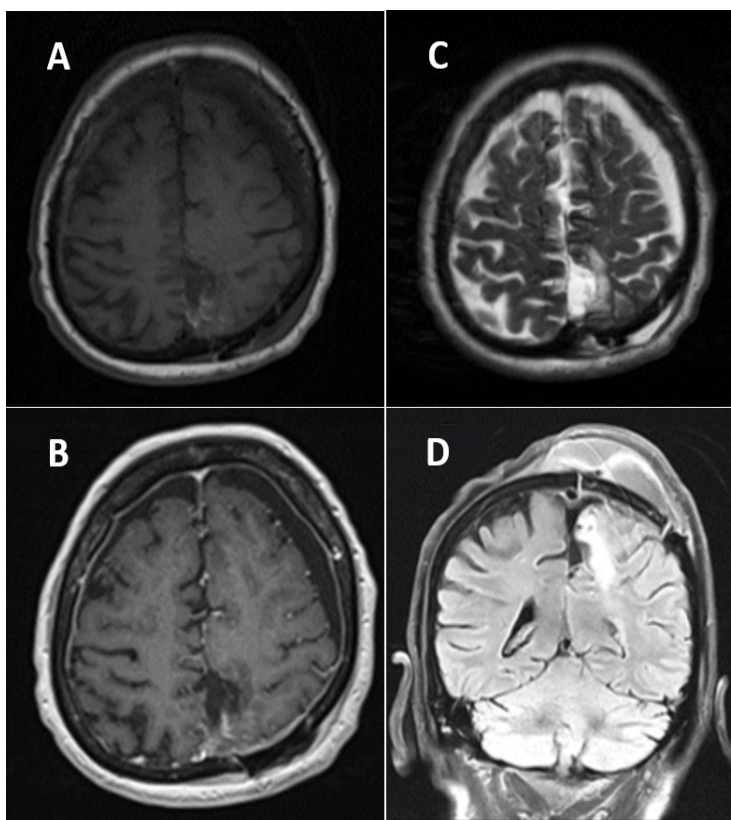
Postoperative MRI images. A. Axial T1-weighted MRI. B. Axial T2-weighted MRI. C. Axial contrast-enhanced T1-weighted MRI. D. Coronal T1-weighted MRI.
